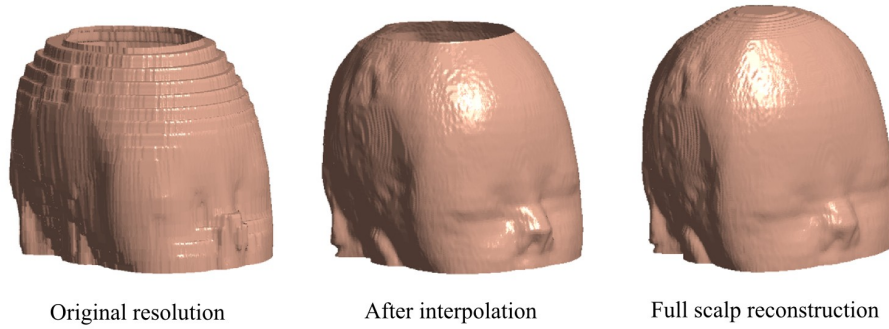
3D reconstruction of low-resolution MRI scans and the result after interpolation. The final results (on the right) shows the appropriate inter-slice resolution.
